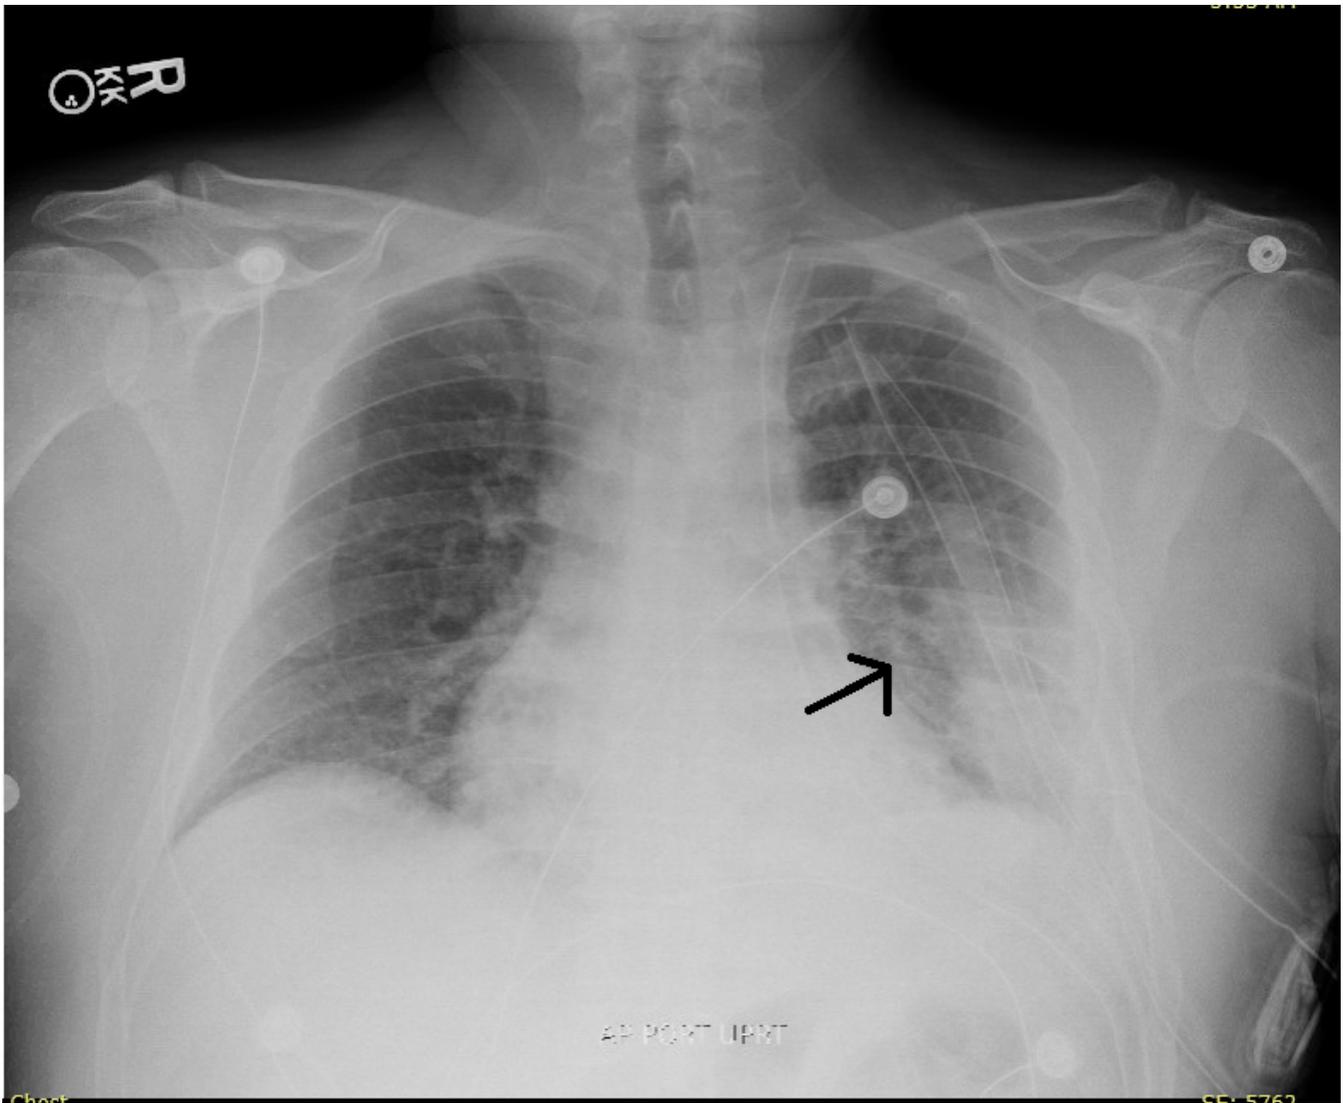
Follow-up chest X-ray imaging done post-VATS on day 7 of hospitalization showed reduction in size of opacity in left hemithorax.
